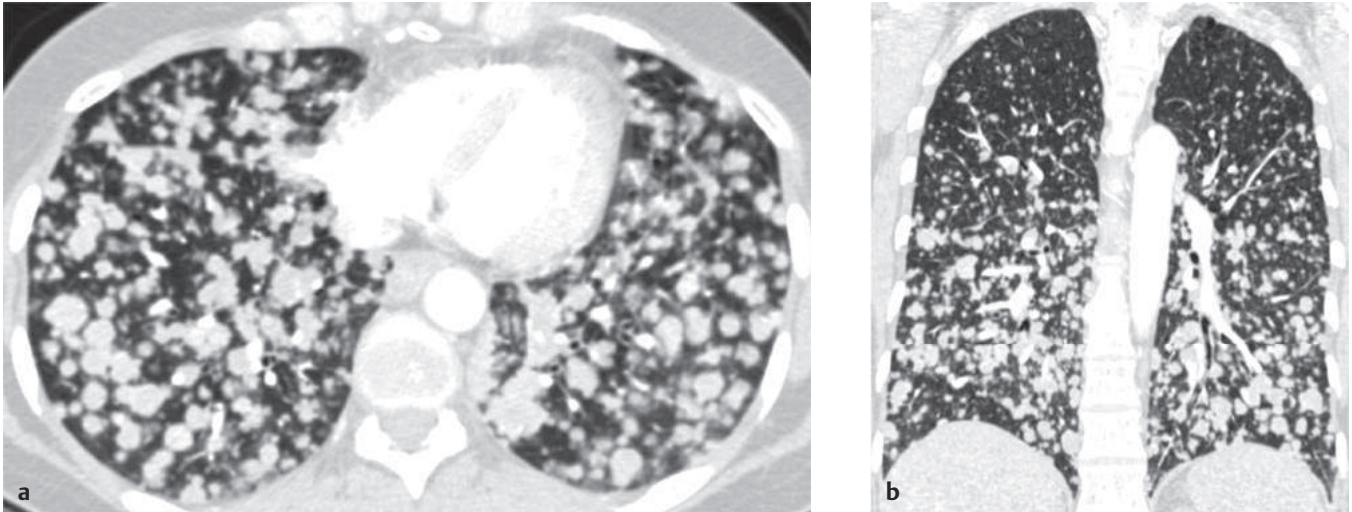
(a) Axial contrast-enhanced computed tomography (CT) shows randomly distributed, well-defined pulmonary nodules. (b) Coronal CT shows lower lobe predominance.
